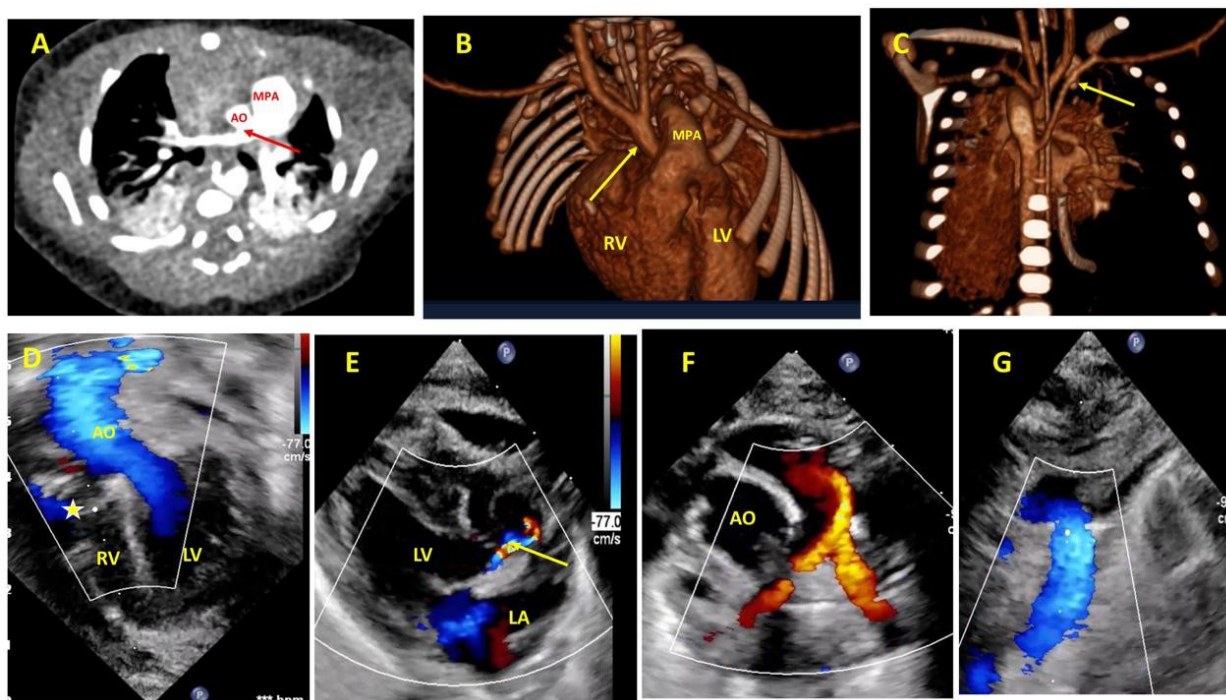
A preoperative MDCT and postoperative echocardiography. (A) MDCT with an axial cut showing the AP window (arrow). (B) MDCT with three dimensional (3D) reconstruction anterior projection showing dilated MPA with type B interruption of the aortic arch (arrow). (C) MDCT with 3D reconstruction posterior projection showing aberrant right subclavian artery arises distally from the ductal arch (arrow). (D) Postoperative TTE with an apical 4-chamber view showing no residual VSD across the VSD patch (asterisk) with no LVOTO. (E) Postoperative TTE with a parasternal long-axis view showing mild aortic insufficiency (arrow). (F) Postoperative TTE with a parasternal short-axis view showing a patent RV-MPA conduit with moderate to severe pulmonary insufficiency (red flow). (G) Postoperative TTE suprasternal view showing patent aortic arch. Abbreviations: MDCT, multidetector computed tomography; TTE, transthoracic echocardiography.
